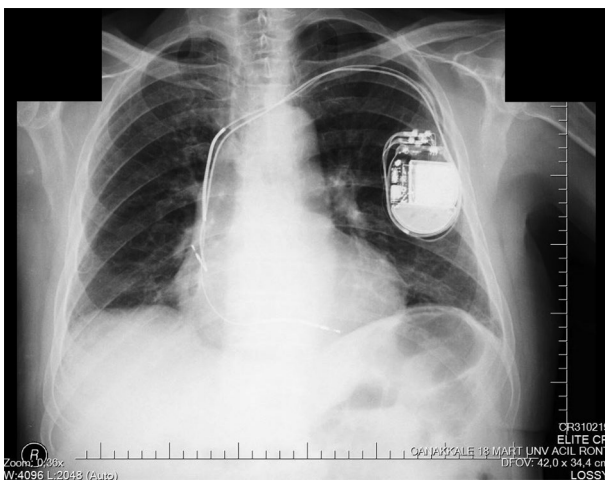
Pacemaker appearance on X-ray.
